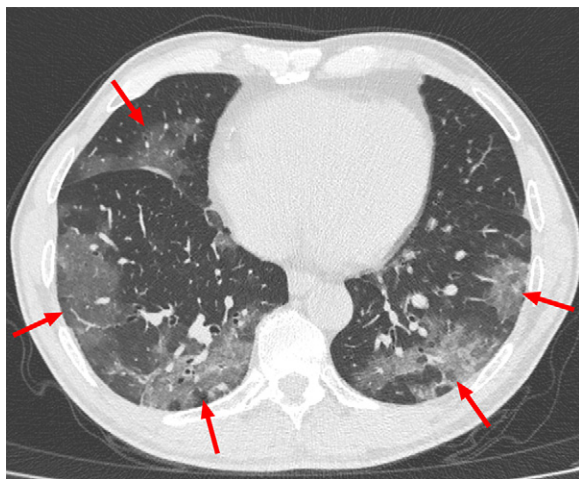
Example of typical CT imaging features for COVID-19 in a 55-year-old male patient. Chest CT image shows bilateral multifocal ground-glass opacities (arrows), which showed a posterior part/lower lobe predilection and mainly peripheral/subpleural distribution.
